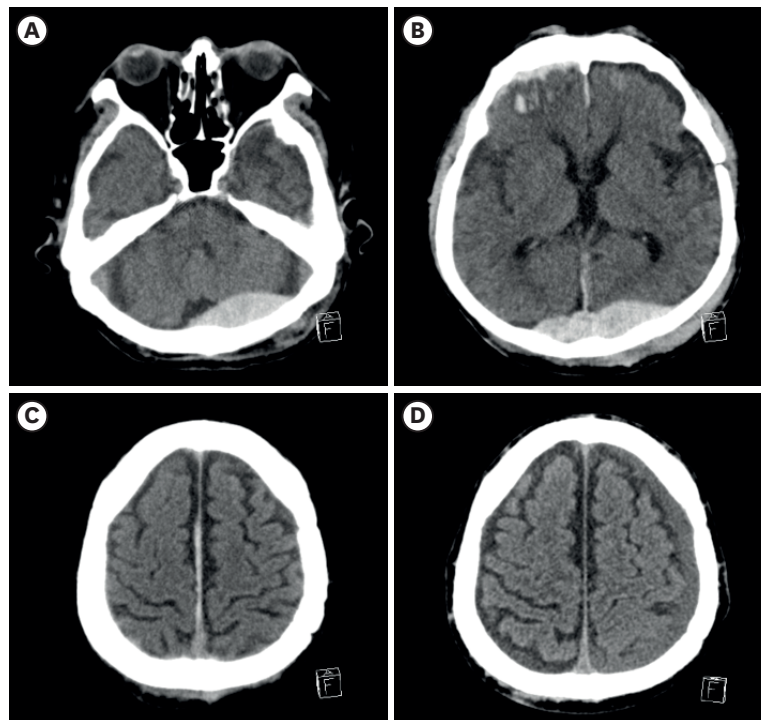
Brain CT scan after traumatic brain injury 2 months ago. (A) CT scan shows AEDH in the left cerebellum. (B) CT scan shows AEDH in the bilateral parietooccipital region with a maximum thickness of 18 mm, bifrontal cerebral contusion, and ASDH and traumatic subarachnoid hemorrhage in the right frontal region. CT scan also shows widening of Sylvian fissure. (C) CT scan shows interhemispheric ASDH, widening of interhemispheric fissure, and cortical sulci. (D) CT scan taken 1 month later shows left CSDH with maximum thickness of 8 mm. CT: computed tomography, AEDH: acute epidural hematoma, ASDH: acute subdural hematoma, CSDH: chronic subdural hematoma.
